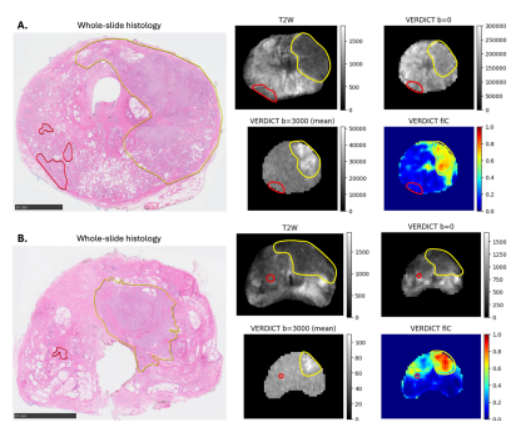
Examples where median fIC of invisible lesions is below threshold. Invisible lesions are outlined in red, reported lesions in yellow. A. Reported lesion in left apex (Likert 5, 3+4 with tertiary pattern 5 (<5%)). Non-reported GS 3+4 lesions on the right, invisible on VERDICT-MRI. B. Reported lesion in left PZ (Likert 4, GS 4+3). Non-reported GS 3+4 lesion on the right, invisible on VERDICT-MRI.
